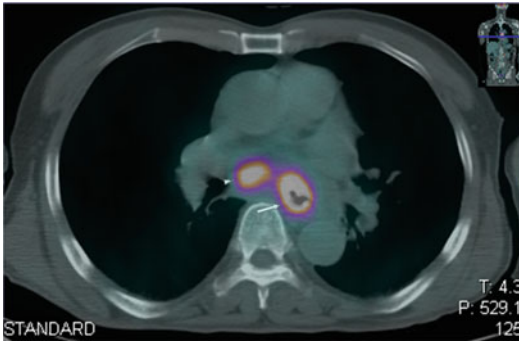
Midesophageal cancer with lymph node metastasis on a PET/CT combined image: selected transverse PET/CT image of the midchest shows a markedly increased uptake of ^{18}F -FDG in the esophagus (arrows) and periesophageal lymph node. Bigger arrow and arrow-head in Fig. 22.1
